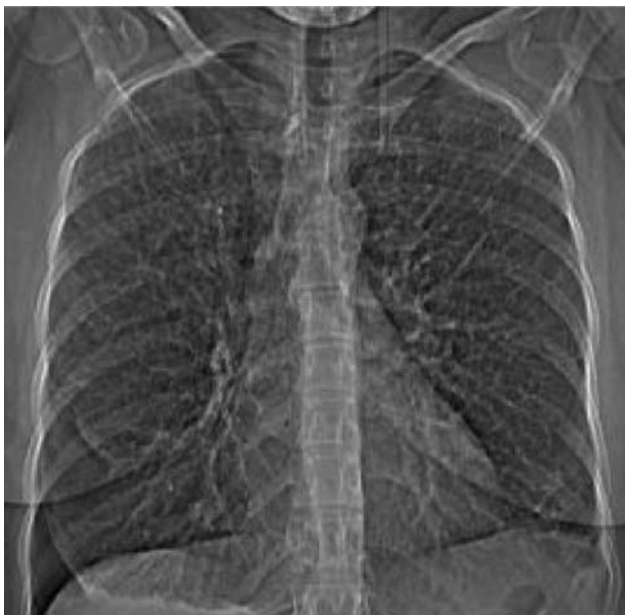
Normal chest radiograph upon admission.
